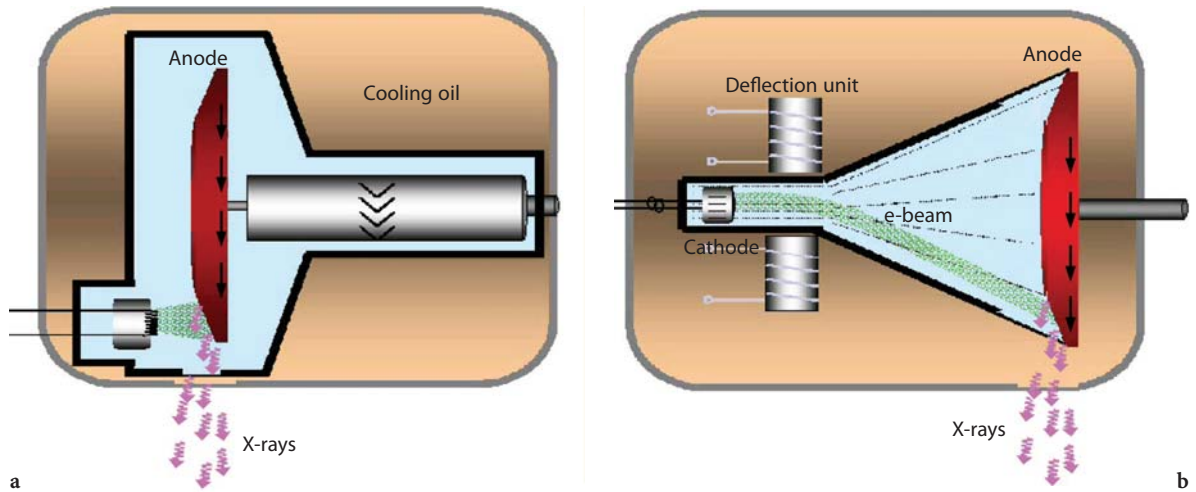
A conventional X-ray tube (a) and a rotating-envelope tube (b). The electrons emitted by the cathode are represented by green lines, the X-rays generated in the anode are depicted as purple arrows. In a conventional X-ray tube, the anode plate rotates in a vacuum housing. Heat is mainly dissipated via thermal radiation. In a rotating-envelope tube, the anode plate constitutes an outer wall of the tube housing and is in direct contact with the cooling oil. Heat is effectively dissipated via thermal conduction, and the cooling rate is significantly increased. Rotating-envelope tubes have no moving parts and no bearings in the vacuum
